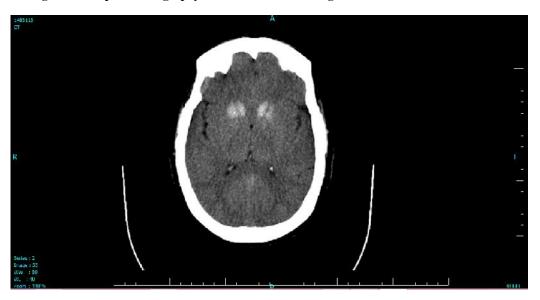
Computed tomography scan of the brain showing bilateral basal ganglia calcifications
